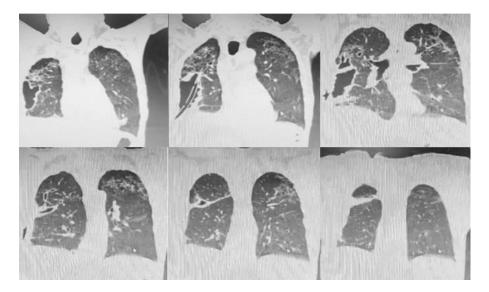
Simple CT of the Thorax on the 1st post-surgical day
